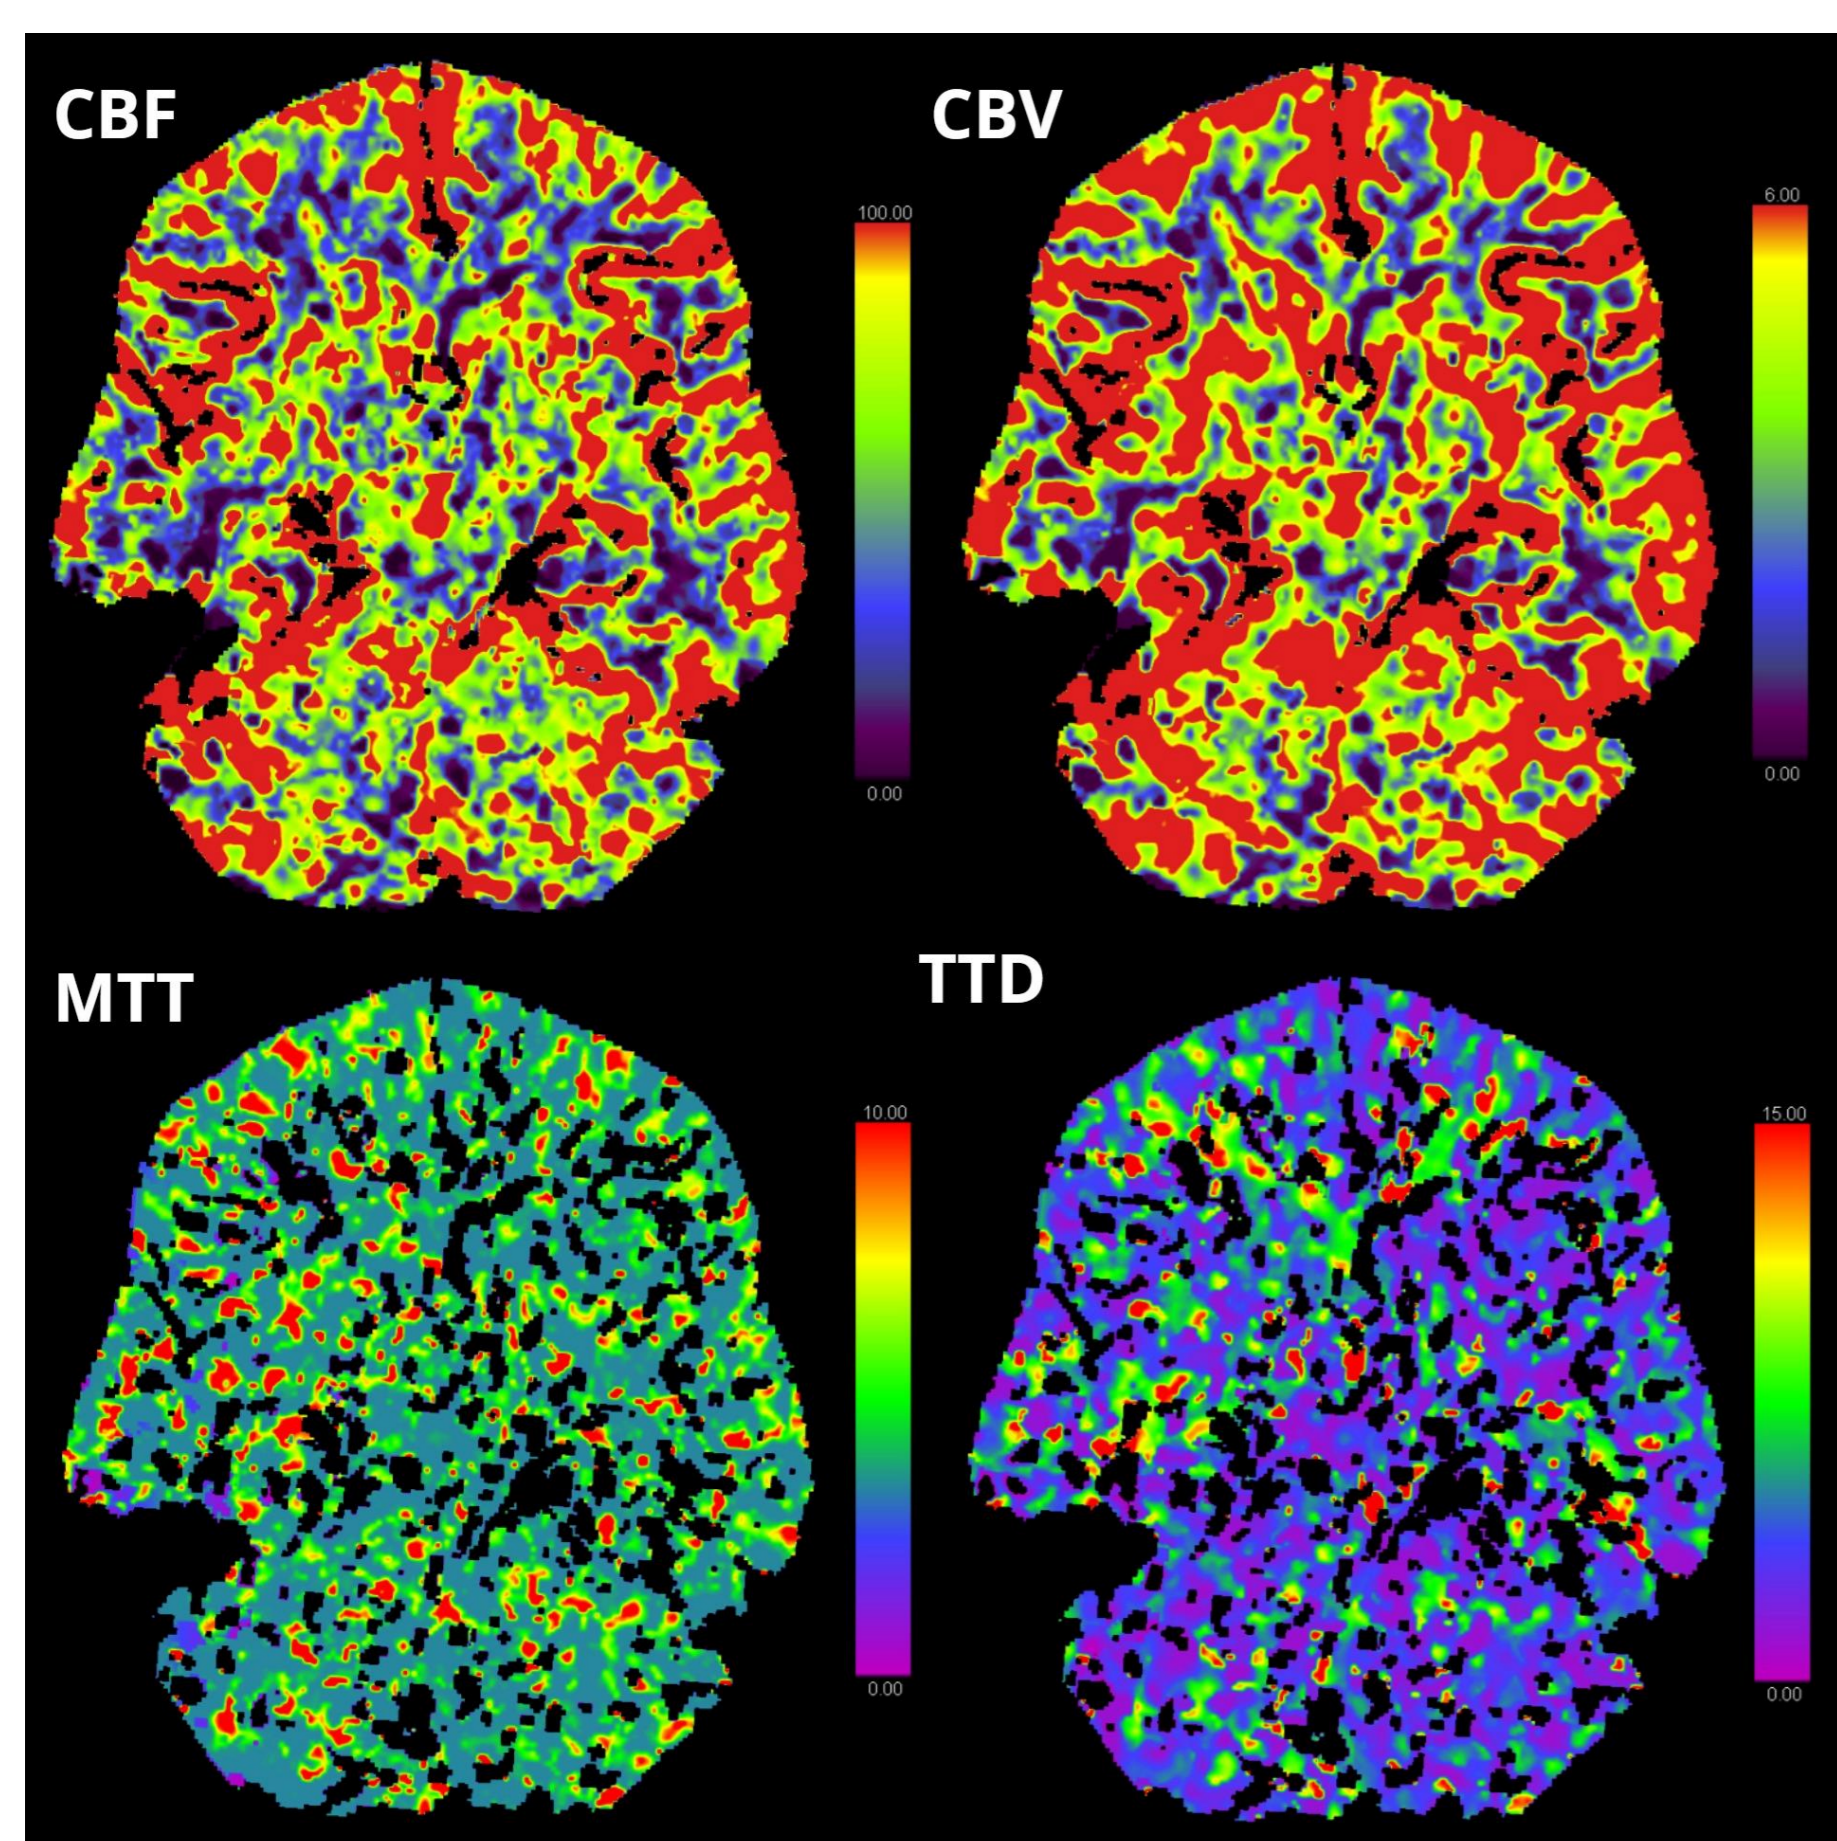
Preoperative brain CT perfusion data indicated a CBV of 3.5 mL/100g, CBF of 32.6 mL/100g/min, and MTT of 6.8 seconds in white matter; and a CBV of 5.7 mL/100g, CBF of 75.6 mL/100g/min, and MTT of 6.1 seconds in gray matter of the MCA territory.
